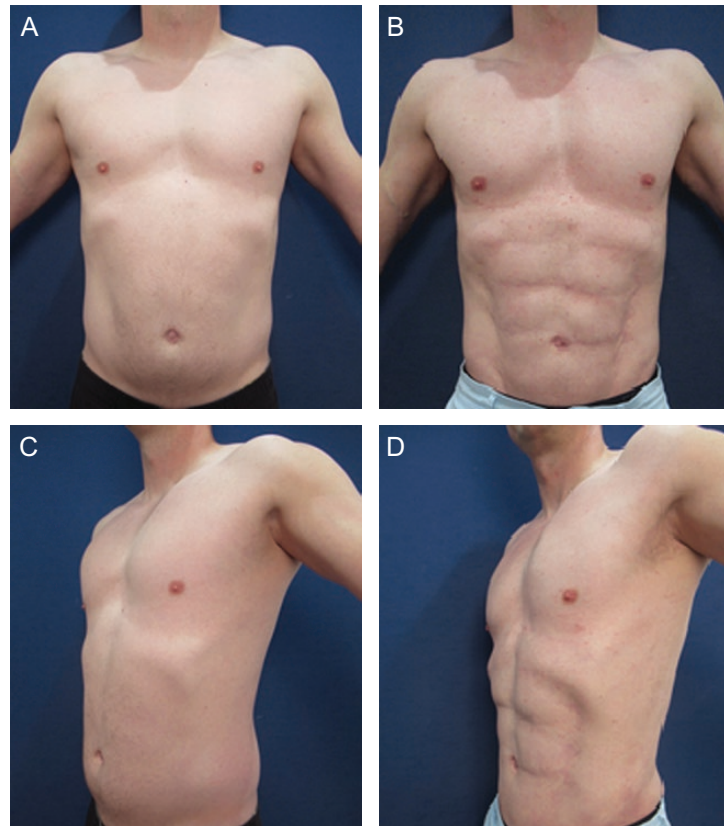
Male chest contouring to create a masculinized armor plate appearance. A 37-year-old male (A, C) before and (B, D) 4 months following ultrasound-assisted liposuction of the abdomen, back, lateral chest, neck, and fat grafting to the chest. Patients demonstrates defined chest borders and a more masculinized chest postoperation.
